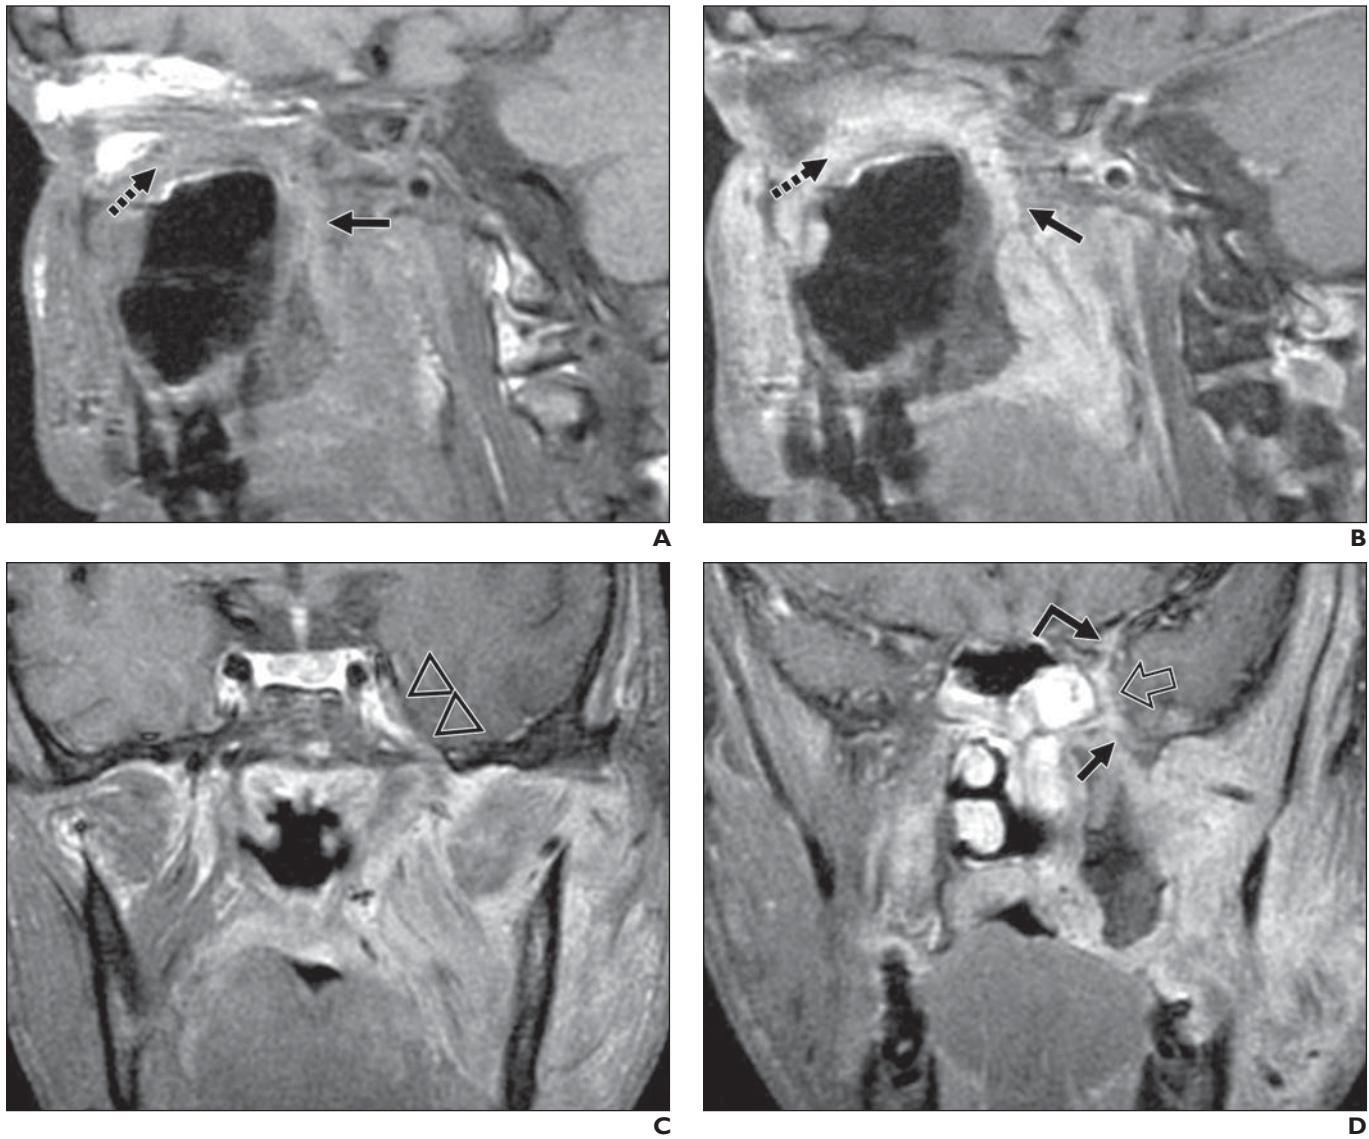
44-year-old woman with granulomatosis with polyangiitis. A–D, Sagittal T1-weighted image (A), contrast-enhanced T1-weighted image (B), coronal contrast-enhanced T1-weighted image (C), and coronal T1-weighted image (D) show extensive inflammatory changes involving masticator space, orbit (dashed arrows, A and B), and buccal space. Inflammatory changes in masticator space involve muscles of mastication and extend to skull base, with associated thickening and enhancement of third division of trigeminal nerve (triangles, C). Orbital inflammation extends posteriorly to involve superior (angled arrow, D) and inferior (open arrow, D) orbital fissures as well as pterygopalatine fossa (solid straight arrows, A, B, and D).
